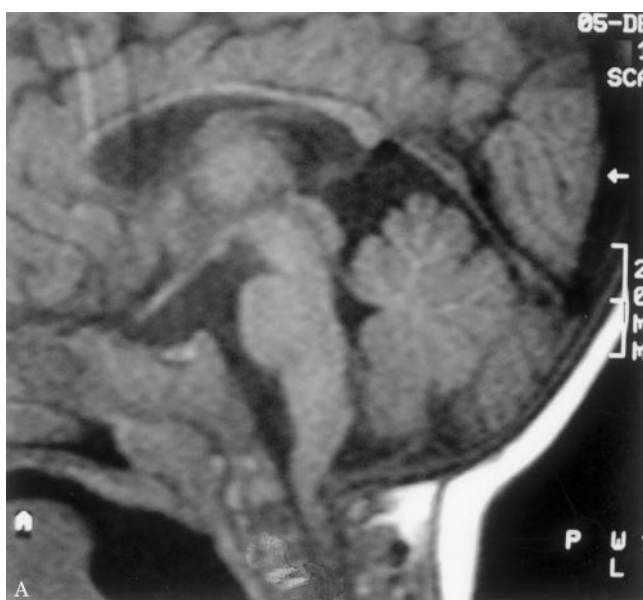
Midsagittal T1-weighted MRI of the lower brain, showing a narrow foramen magnum, causing indentation of the cervicomedullary junction.
